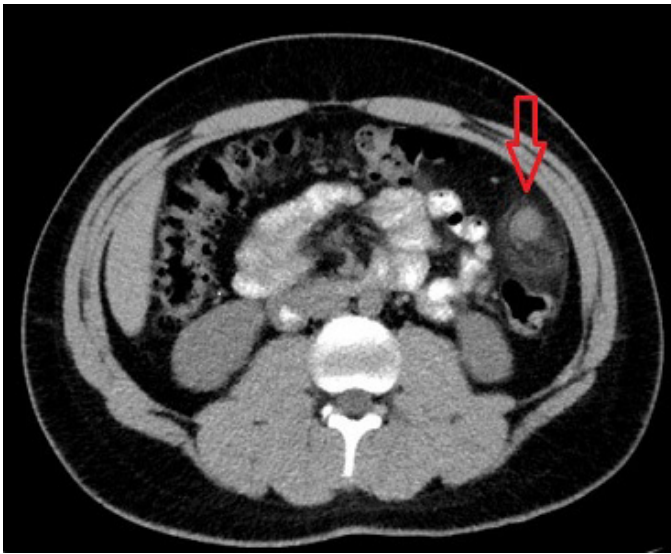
Abdominal CT showing a hypodense, homogeneous mass with fat stranding in the left upper quadrant.
